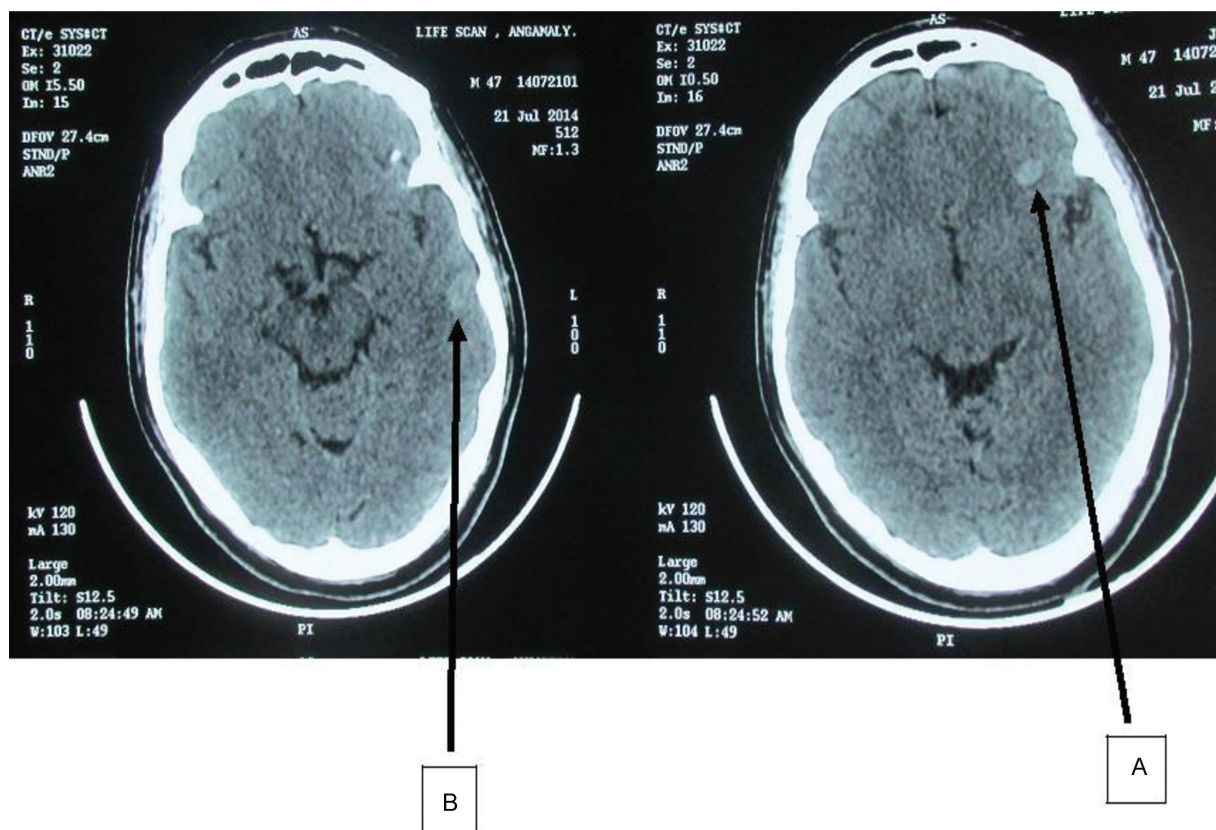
Initial CT scan of the brain. (A) A small hemorrhage in the left lobe and (B) a suspicious hemorrhage in the left temporal lobe with no significant mass effect. CT, computed tomography.
